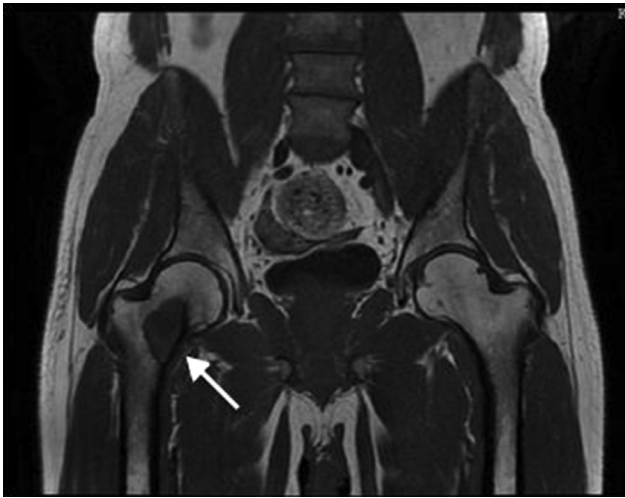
Preoperative coronal T1-weighted MRI demonstrated a hypointense lytic expansile mass lesion at the trochanter minor of the right femoral neck (arrow). Significant contrast enhancement in the mass lesion and some degree of soft tissues expansion was noted.
